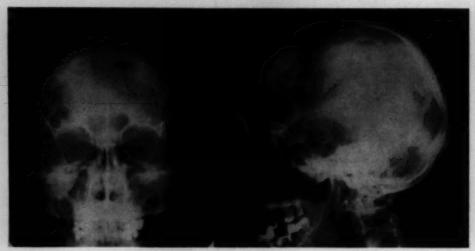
(Nicholls). Case 1. Posteroanterior, and right lateral X-ray pictures of skull showing the osteolytic lesion in the right supraorbital ridge, frontal squama, and orbital roof.
